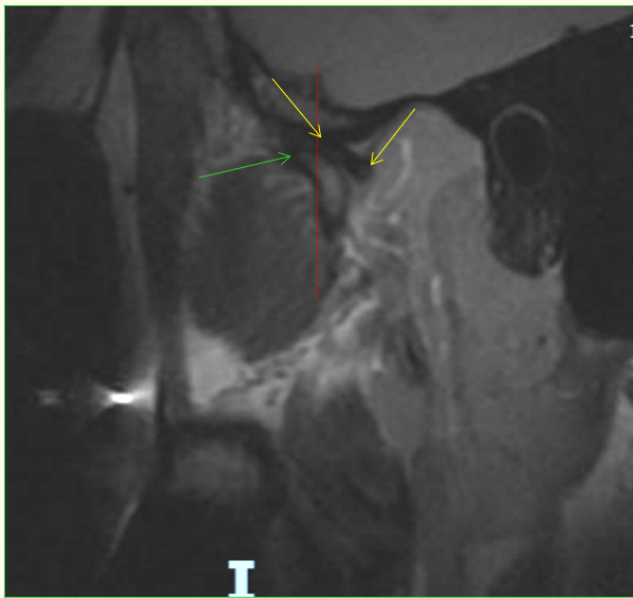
MRI of the right TMJ on sagittal view, opened mouth. Hyperexcursion of the right condyle passing the limits of articular disc and the most inferior aspect of the articular eminence is appreciated. *Yellow arrows:* anterior and posterior limits of the articular disc. *Green arrow:* anterior limit of the most anterior aspect of the right articular condyle. *Red arrow:* midline dividing the anterior and posterior limits of the articular eminence.
